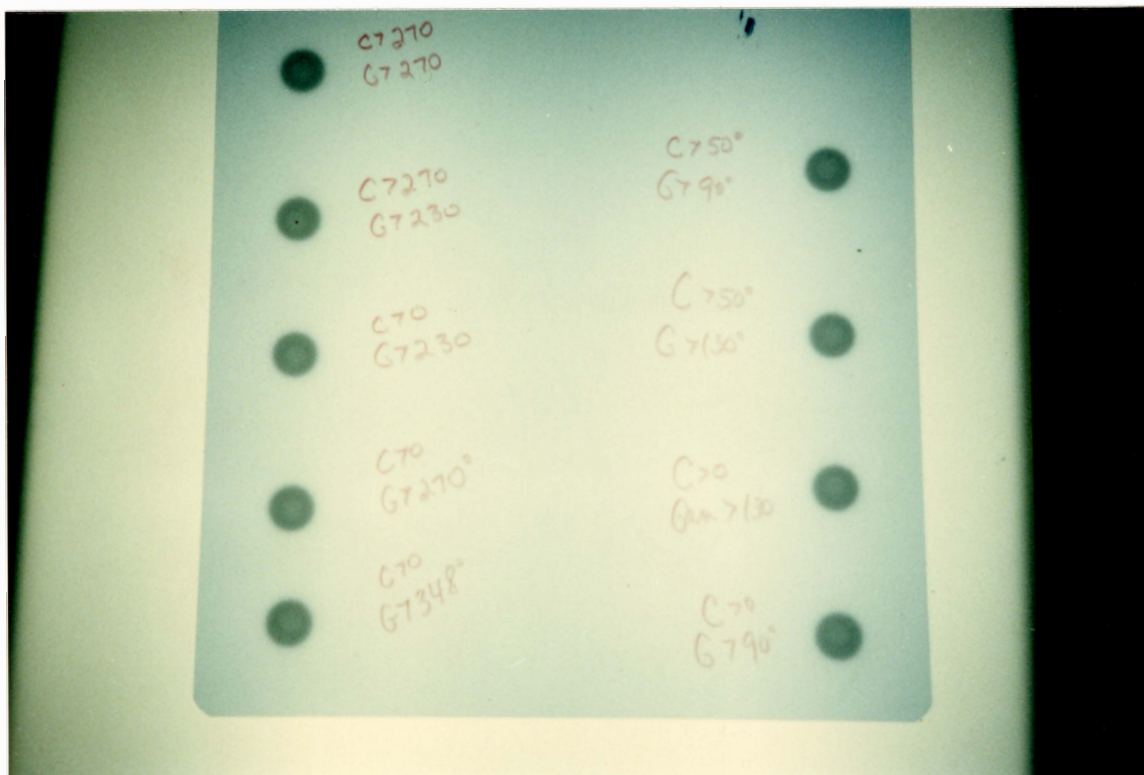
X-ray film of 9 arcs taken during the LINAC Verification Procedure.
